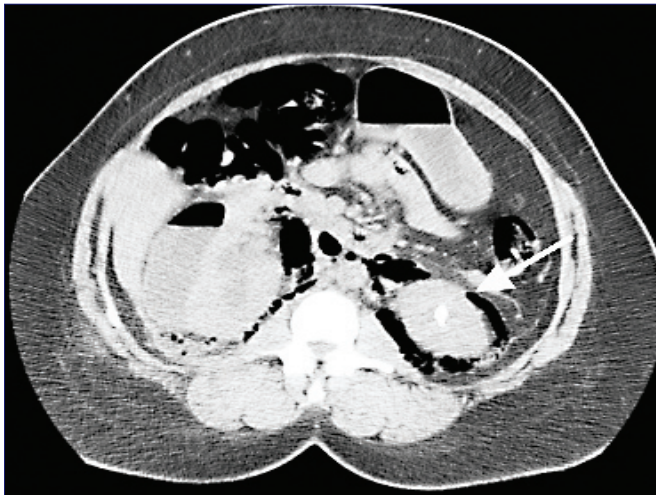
CT without contrast - demonstrates bilateral perinephric gas, with a right perinephric collection. Left calculus seen.
